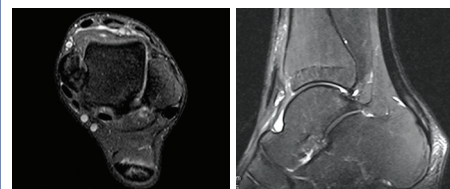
pre-treatment T2 MRI of the Achilles tendon in A.H. showing a 2.5 cm partial tear ■
